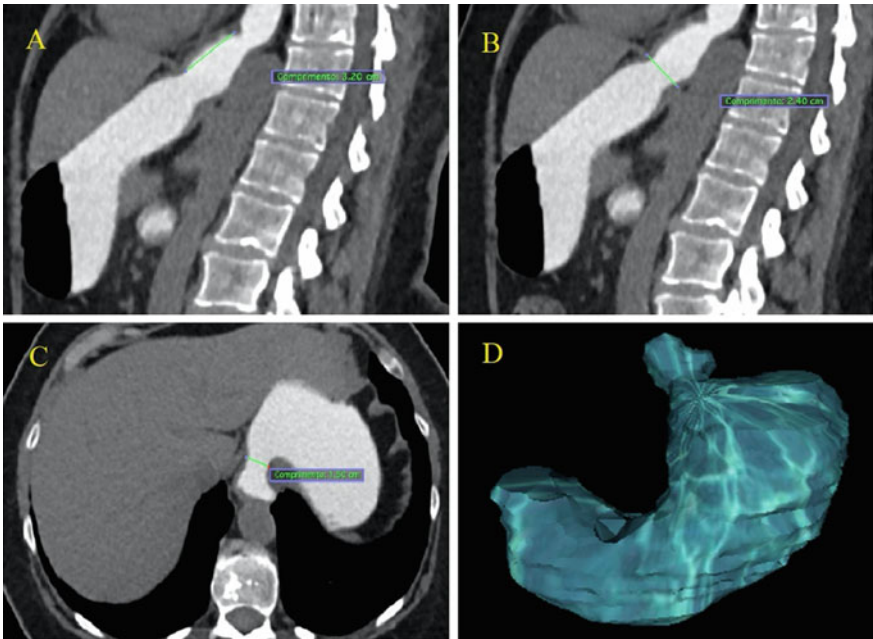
Type I hiatal hernia. A Distance of the esophagogastric junction to hiatus of 3.2 cm in sagittal CT section with oral contrast. B Anteroposterior diameter of the hiatus of 2.4 cm in a sagittal CT section. C Side-to-side diameter of the hiatus of 1.50 cm in axial CT section. D Gastric reconstruction in 3D, with demonstration of the herniated stomach
